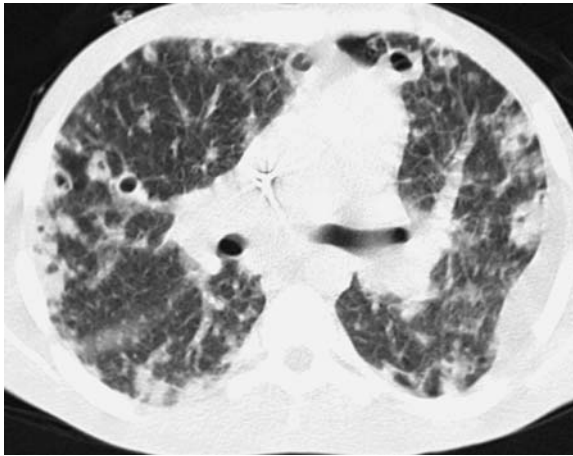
Transverse CT scan in double-lung transplant recipient. CT scan shows multiple cavitary lesions corresponding to pneumatoceles after staphylococcal infection
